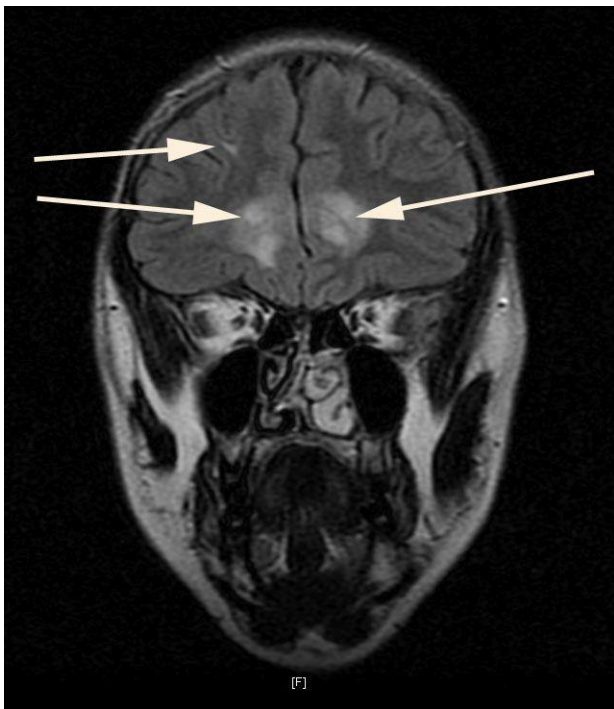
MRI coronal section FLAIR showing demyelinating lesions (arrows).
